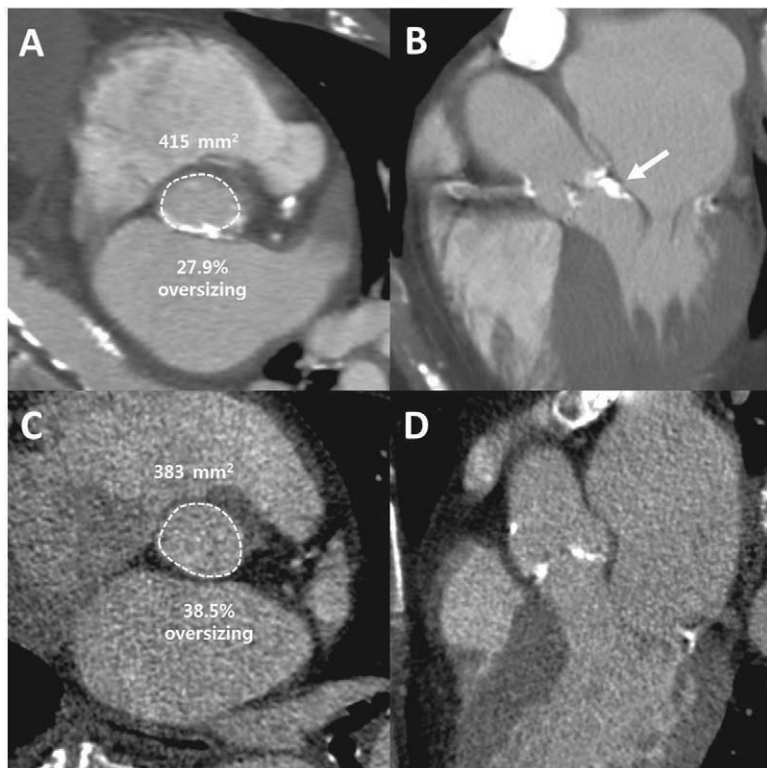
Case examples of 2 patients who underwent TAVR with a 26-mm (A, B) and a 23-mm (C, D) SAPIEN XT valve. In these cases, significant annular area oversizing (27.9% and 38.5%, respectively) resulted in different outcomes. The case showed in A and B (MDCT double-oblique transverse and coronal projections, respectively) with severe LVOT calcification (white arrow) experienced annular rupture during TAVR complicated by procedural death. The second case (C and D) displays an absence of LVOT calcification and, despite comparable prosthesis oversizing, this patient underwent an uneventful TAVR. LVOT indicates left ventricular outflow tract; MDCT, multidetector computed tomography; and TAVR, transcatheter aortic valve replacement.
